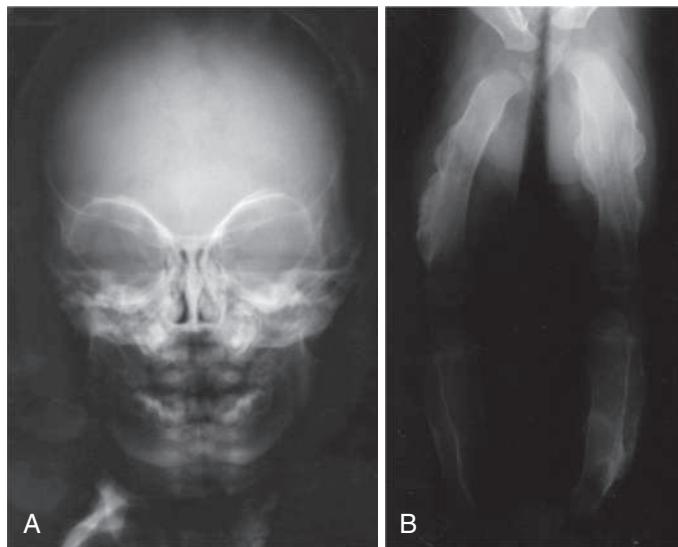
A, Radiograph of a 5-mo-old infant showing hyperostosis of the mandible. B, Radiograph of a 5-mo-old infant showing hyperostosis of both legs. (From Kamoun-Goldrat A, le Merrer M. Infantile cortical hyperostosis [Caffey disease]: a review. *J Oral Maxillofac Surg*. 2008;66:2145–2150. Figs. 1 and 2.)
